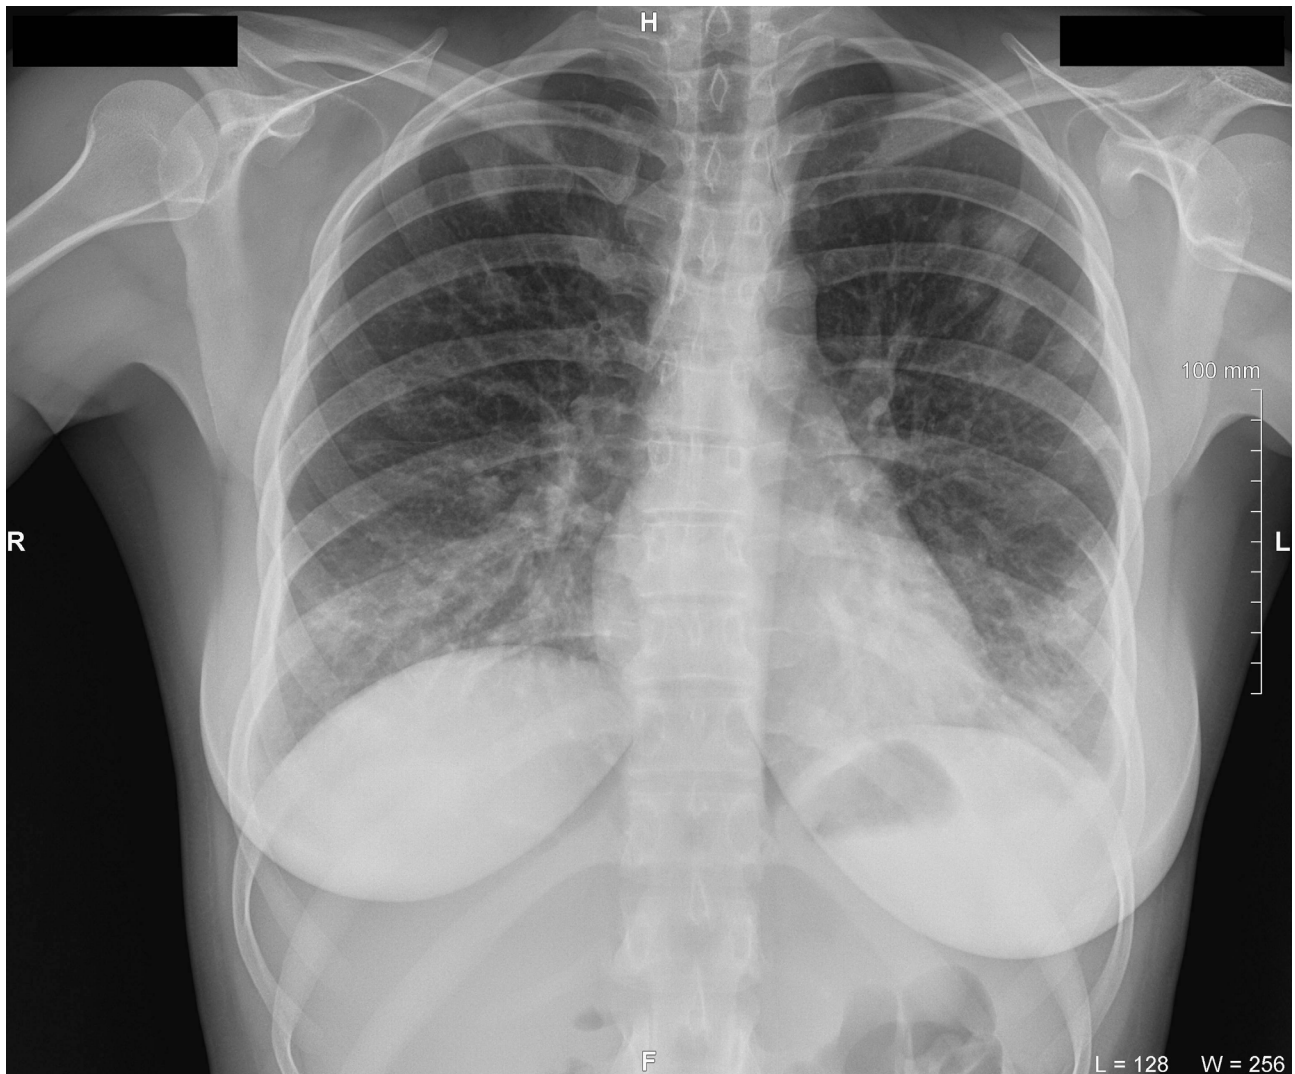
Antero-posterior view of the chest X-ray at day 2 of the treatment of lower lip furuncle complicated by necrotizing fasciitis of the lip. Radiological data corresponds to the bilateral multilobar pneumonia. H, head; R, right; L, left. Printed with permission and copyrights retained by I.I.F.
